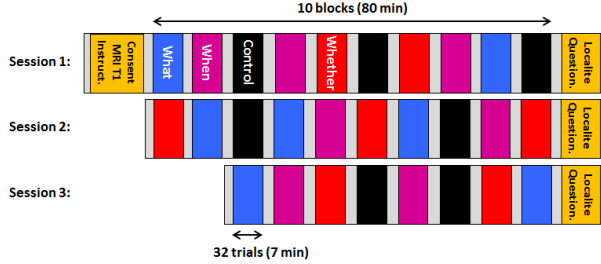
The participants took part in three sessions on three different days, each session was composed of 10, 10 and 8 blocks respectively. The conditions (types of decision to be taken) were assigned pseudo-randomly to the blocks. The first session was preceded by structural T1-weighted MR image acquisition. Each session was followed by electrode position measurements and a short questionnaire. Exemplary sequence of blocks for one of the participants is presented.
